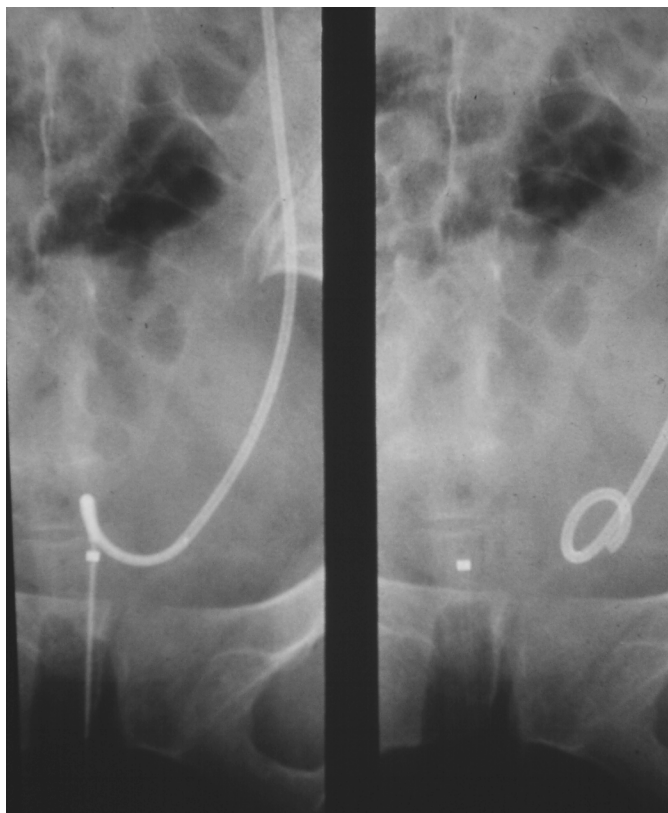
Radiographic appearance as the guidewire is withdrawn and the stent curls in the bladder.
